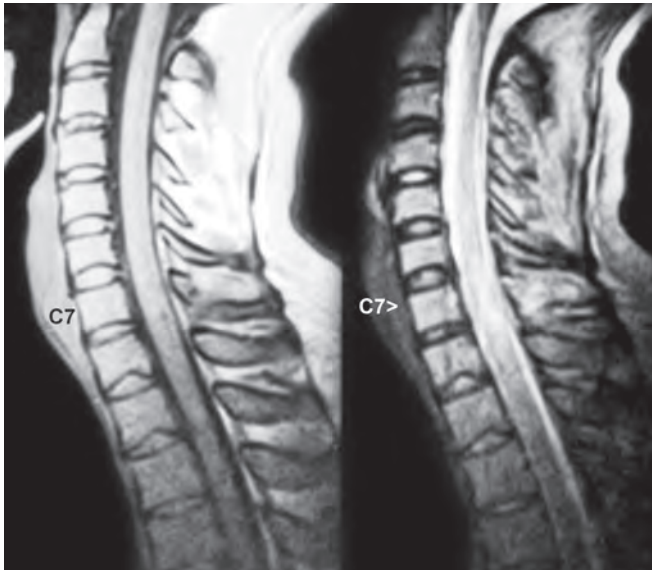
MRI showing intramedullary T2 hyperintensity in a patient with gunshot wound to the soft tissues of the neck
